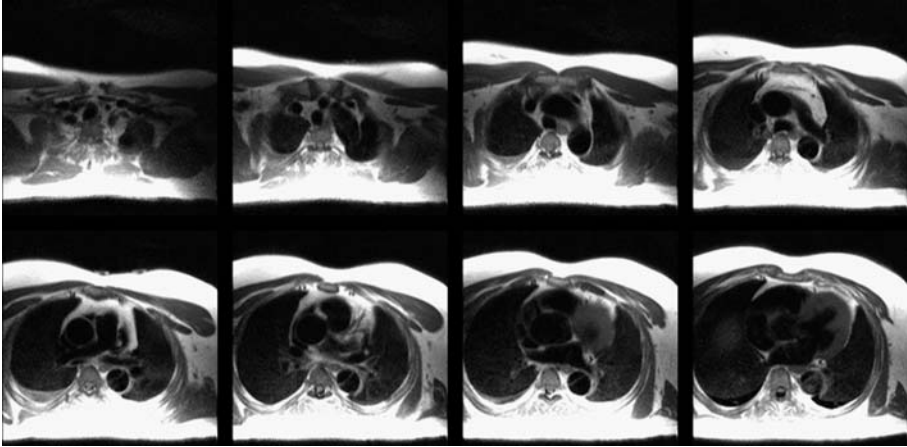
Transverse T2-weighted HASTE sequence in a patient with type A aortic dissection. Blood is visualized as black (black-blood technique). All images are taken in a single breathhold, gated. The intimal flap is clearly delineated.
